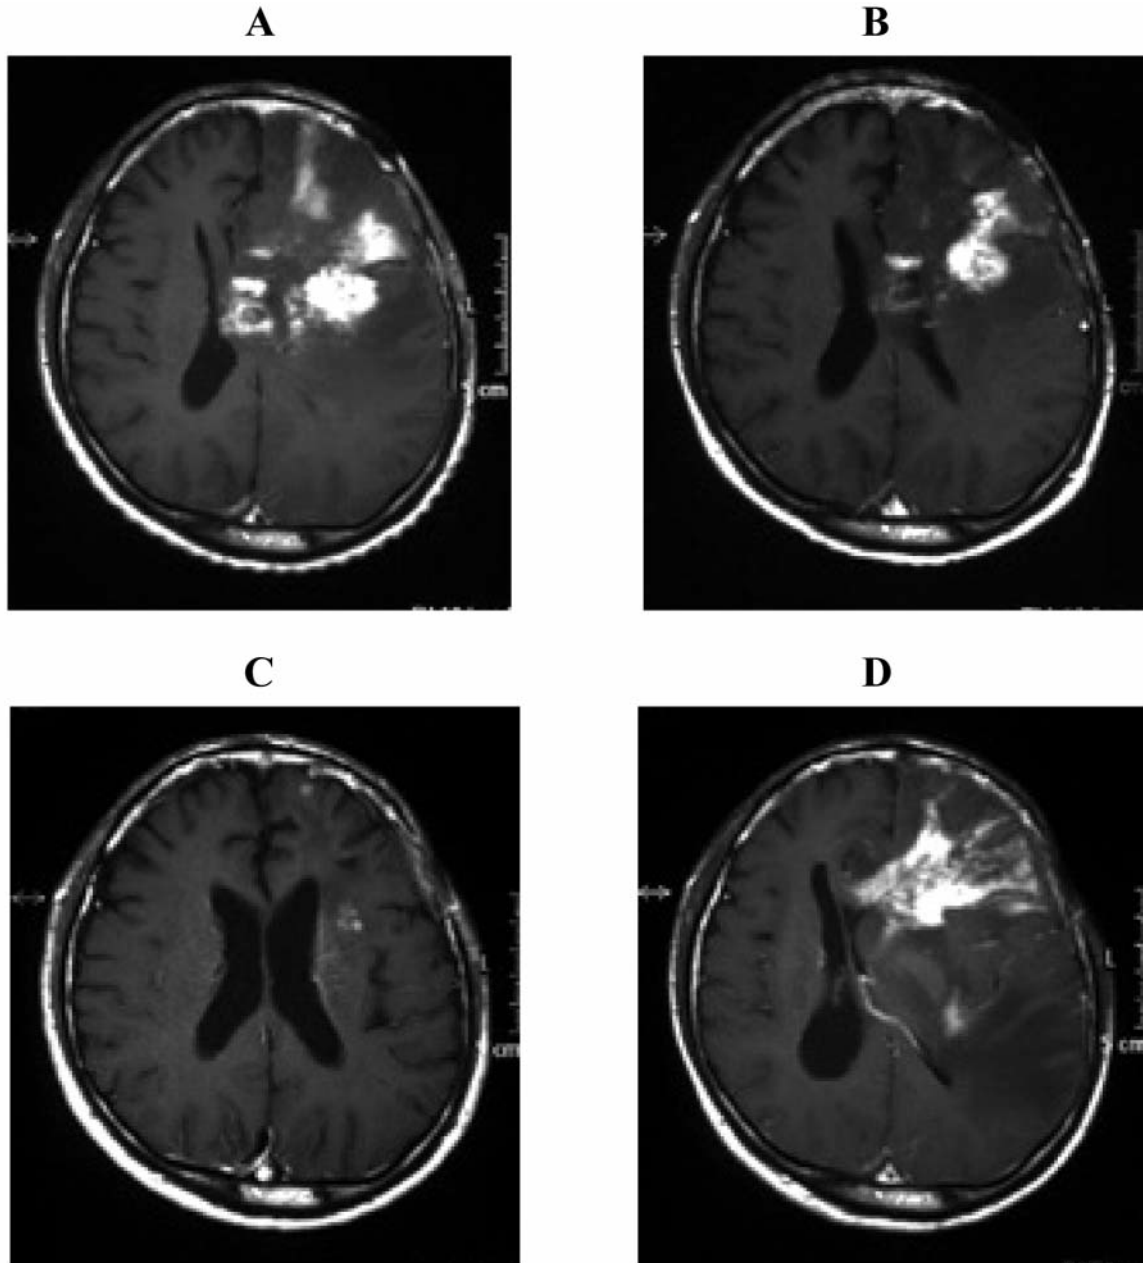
Case 4 with recurrent anaplastic oligodendroglioma. Gadolinium-enhanced MRI obtained at second relapse shows a left frontal mass lesion with heterogeneous enhancement (A). Just after finishing the first cycle of the TMZ regimen, MRI demonstrated shrinkage of the relapsed tumor (B). On finishing 5 cycles of treatment, most of the tumor had disappeared (C). However, repeated relapse was detected and tended to progress rapidly after discontinuation of TMZ chemotherapy (D).
